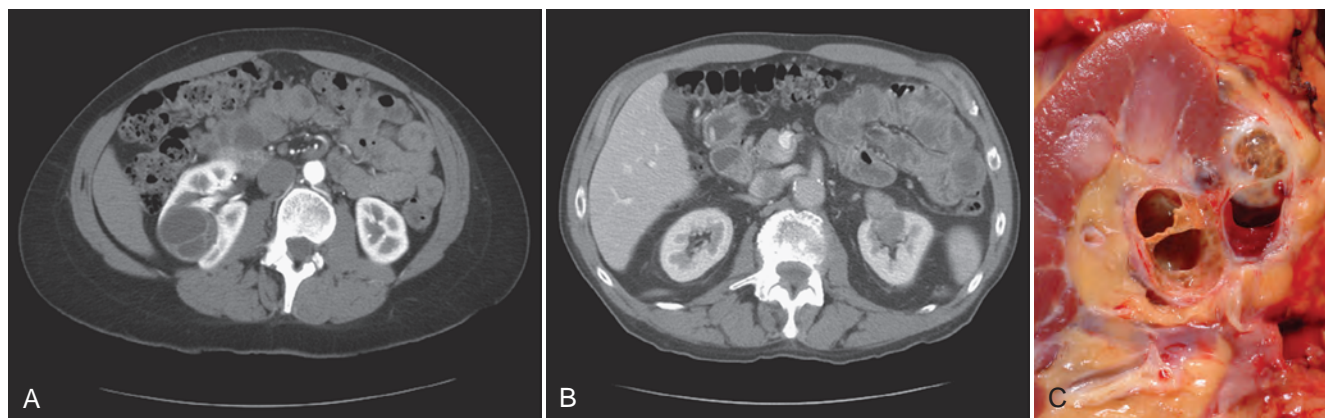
A, Computed tomography (CT) scan of a Bosniak III renal cyst. Thick, irregular septations are present within the cyst. B, CT scan of a Bosniak IV renal cyst, with a solid enhancing nodule. C, Bivalved Bosniak IV renal cyst demonstrating a solid component that proved to be conventional renal cell carcinoma. (Copyright 2009, C. G. Wood.)
